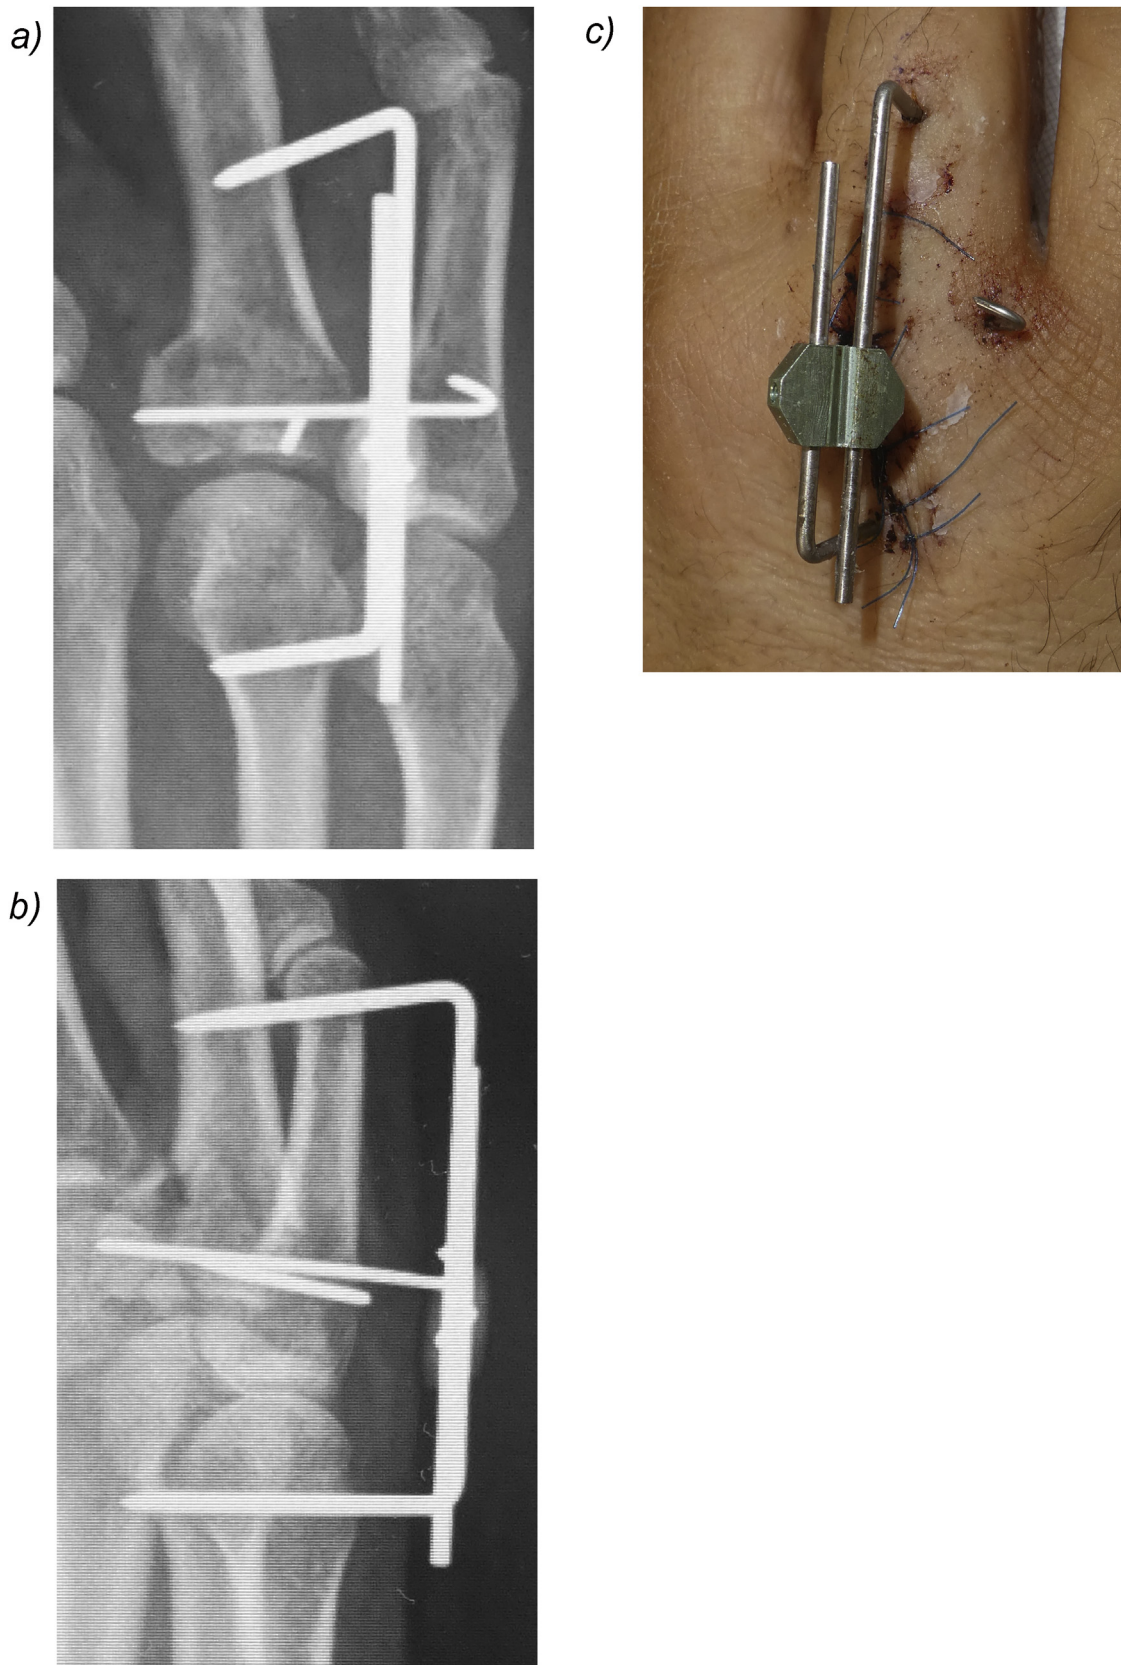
Postoperative X-ray A), B) and macroscopic findings C). The joint fragments were fixed with K-wires, and the Ichi-Fixator was applied to the ring finger metacarpophalangeal joint.
